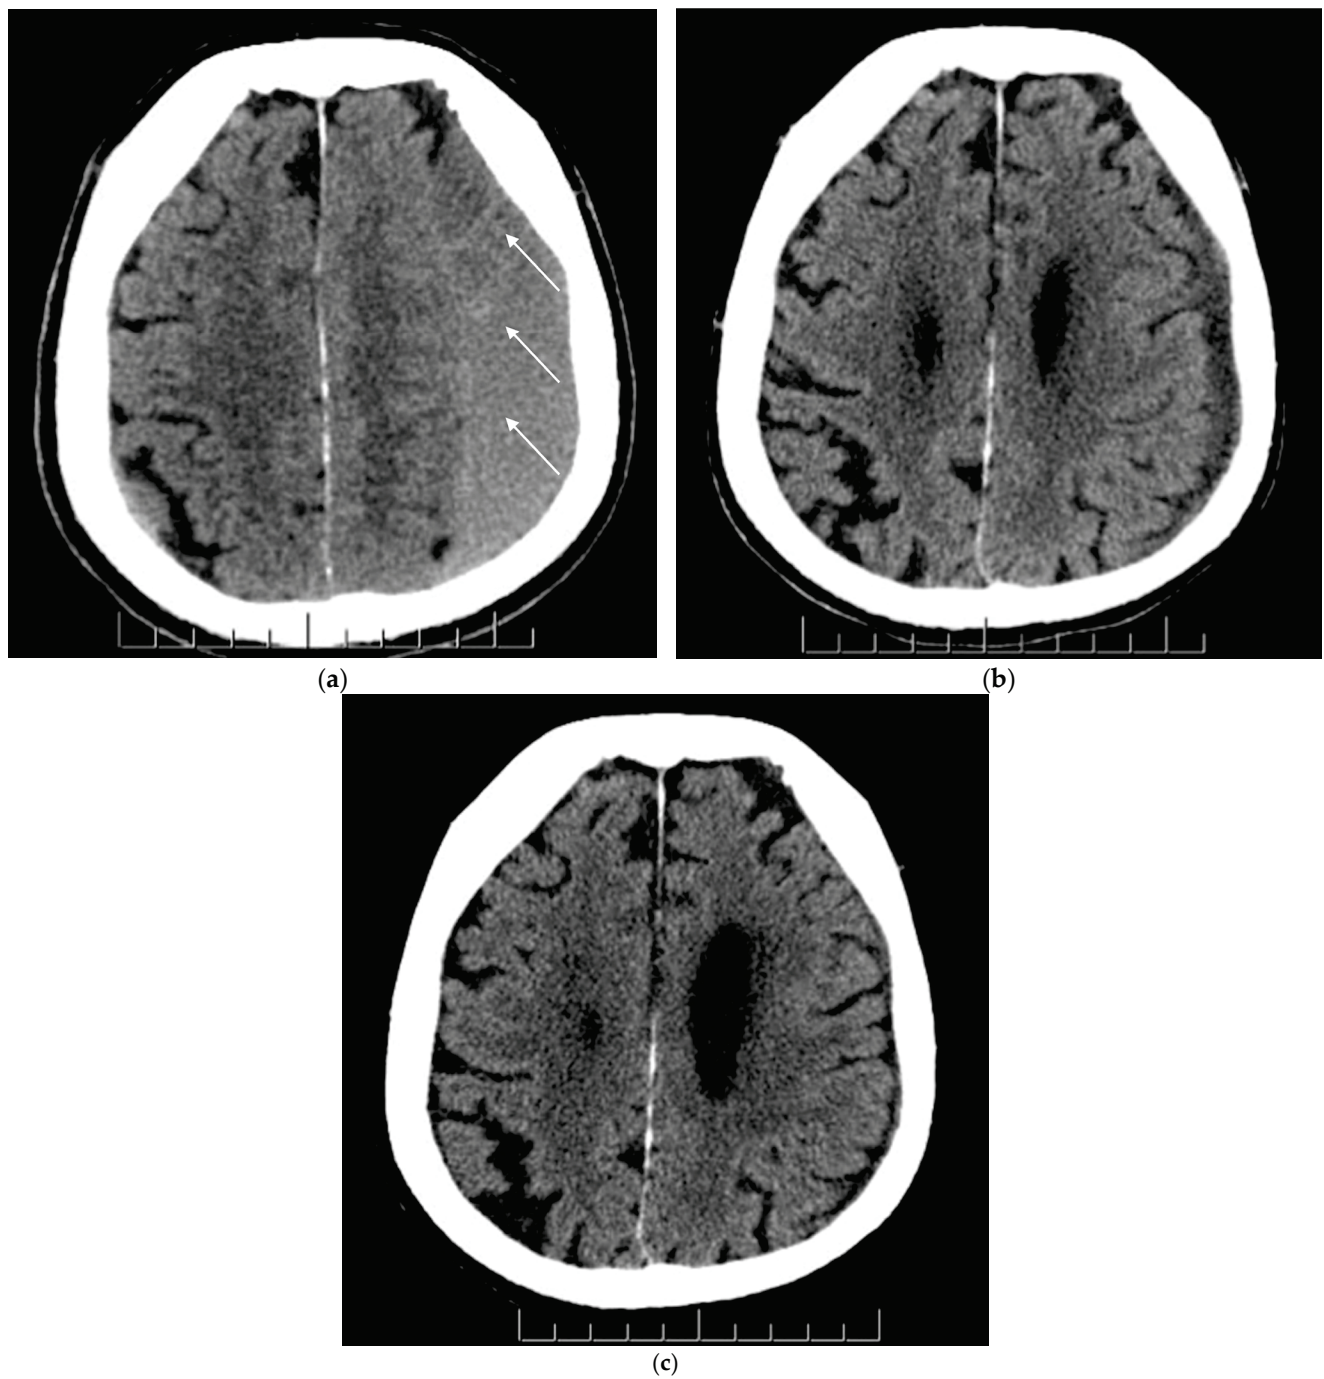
(a–c) Axial view of non-contrast CT head scans before and after MMAE (middle meningeal artery embolization) for the same patient. Figure parts a, b and c represent chronic subdural hematoma (cSDH) pre-MMAE (baseline), at 1–3 months and 3–6 months post-MMAE, respectively. (a) A non-mature mixed cSDH was noticed at baseline on the left cerebral hemisphere with sulcal effacement, obliteration of the left lateral ventricle and slight midline shift to the right. The white arrows demonstrate the mixed cSDH nature; (b) Improvement of the cSDH and mass effect was noticed in 6-week CT scan post-MMAE; (c) A near-complete resolution of cSDH and mass effect was noticed in 5-month CT scan.
